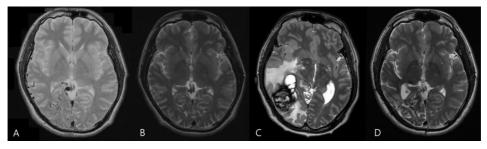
A 21-year-old man (case 5) presented with seizure. A) MRI scan showed AVM at the left occipital lobe. He underwent GKRS twice for AVM. B) MRI scan showed total obliteration of AVM 5 years after the first GKRS. C) He presented with headache and diplopia 11.5 years after the first GKRS. RIOH and severe cerebral edema were identified. He underwent surgical resection of RIOH. D) Follow-up MRI scan at 1 year postoperatively showed improved cerebral edema and no evidence of recurrence.
